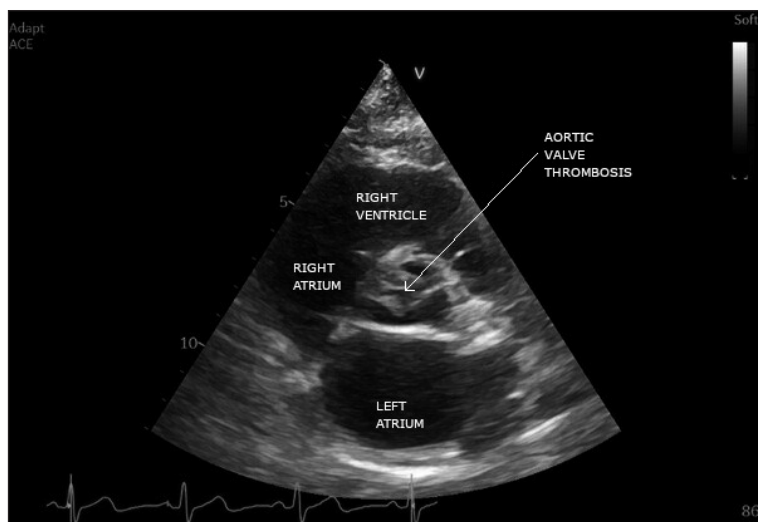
Transthoracic echocardiography (parasternal window, short axis) showing mass (thrombosis) on the right and non-coronary aortic valve leaflets.
